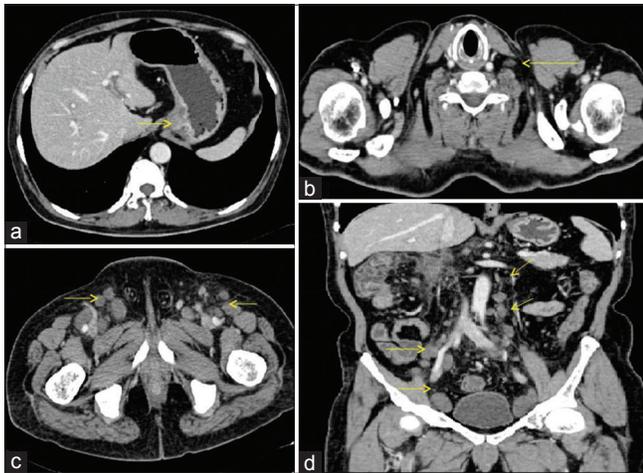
Contrast-enhanced computed tomography abdomen: (a) Axial cuts at the level of gastroesophageal junction showing heterogeneously enhancing wall thickening; (b) Axial cut of neck showing enlarged left supraclavicular lymph node; (c) Axial cut at the inguinal region showing bilateral multiple enlarged nodes; (d) Coronal reconstruction showing multiple enlarged paraaortic, iliac, and pelvic lymph nodes
